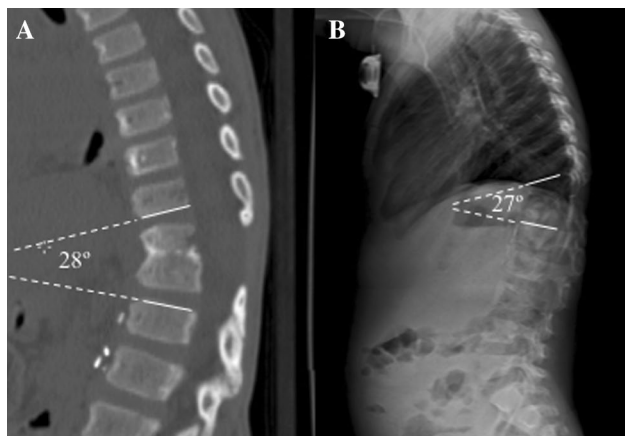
Postoperative a sagittal CT reconstruction at 24 months confirming mature fusion between T10 and T12 with local kyphosis of 28° and b full spine standing radiograph at 42 months showing local kyphosis of 27° but no major deformity
